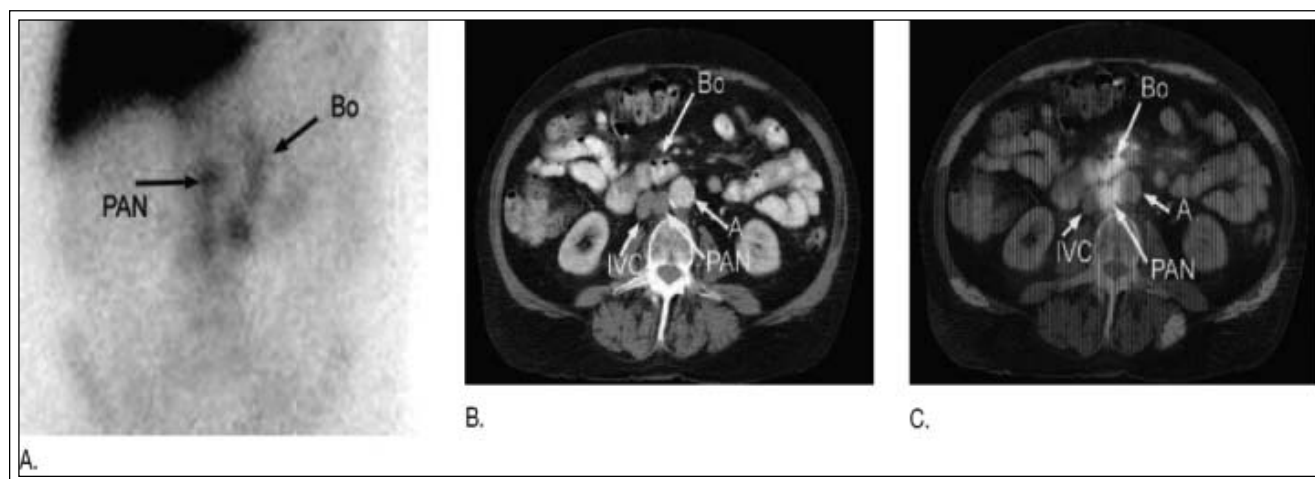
Capromab pendetide and CT scan fused demonstrating high intensity signal in both the intestine, which is the normal excretion of the immunoconjugate, and the para-aortic lymph nodes (PAN). (Courtesy of R. McDonald, MD Anderson Cancer Center, Orlando, FL).
